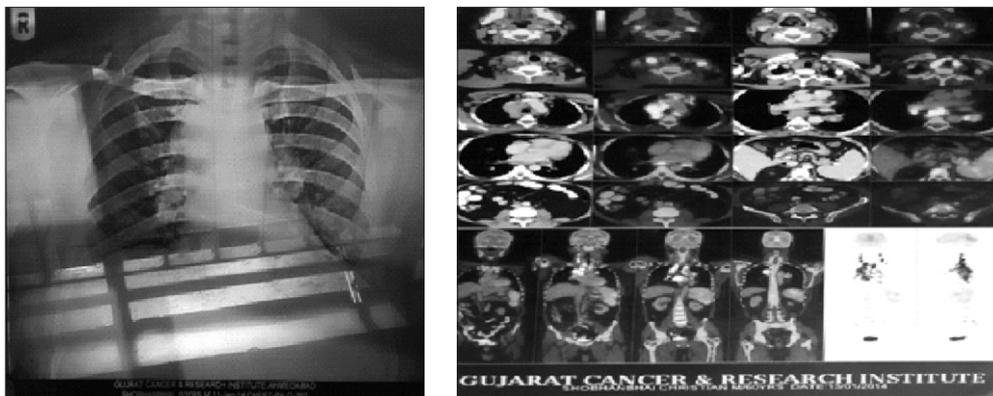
a Normal Chest X-Ray b Normal PET scan after 1 month
